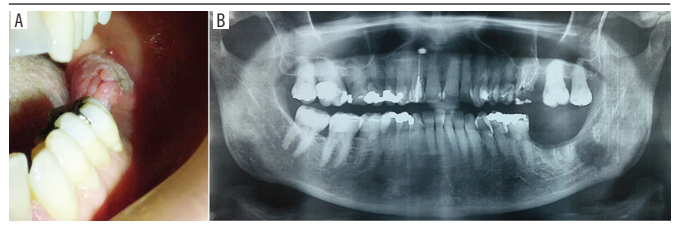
A) exophytic mass located at the left mandibular gingiva. Previous dental extraction and chronic suppurative osteomyelitis were noticed in this area; B) panoramic radiograph showing an osteolytic area with irregular and ill-defined borders
